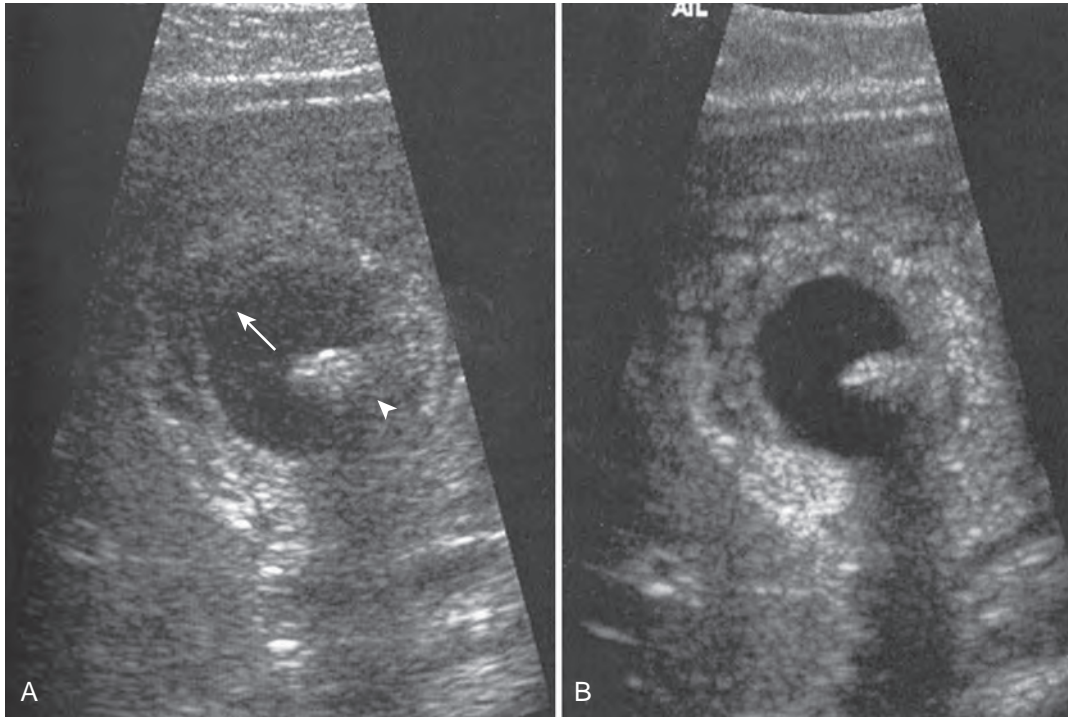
A, Standard gray-scale image of a cyst containing a mural nodule (*arrowhead*). Note the artifactual echogenicity within the cyst (*arrow*). B, The same structure on harmonic scanning is seen more clearly. There is less artifact within and distal to the cyst. (From Merritt CRB. *Physics of ultrasound*. In: Rumack CM, Wilson SR, Charboneau JW, Johnson J, editors. *Diagnostic ultrasound*. 3rd ed. St. Louis: Mosby; 2005. p. 3–34.)
